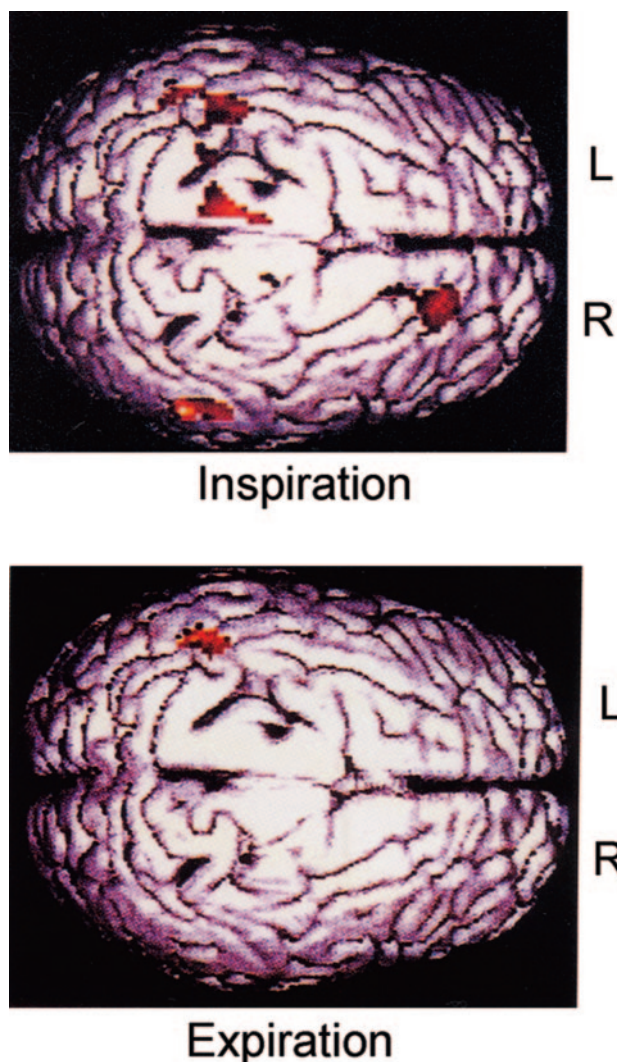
Functional magnetic resonance imaging in a human, during a breathing maneuver. View is from above, with the frontal lobes on the right and the occipital lobes on the left. The colored areas are active during the specified activity. (From Reference 11, with permission.)
